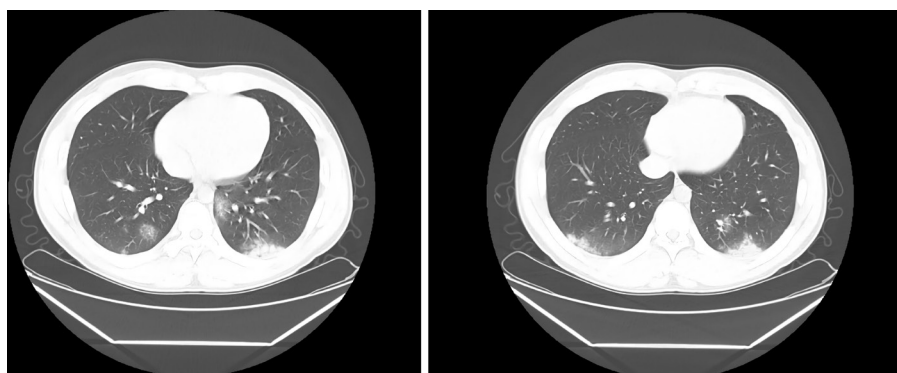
Lung CT image. The image showed multiple ground-glass opacities in bilateral lungs.
